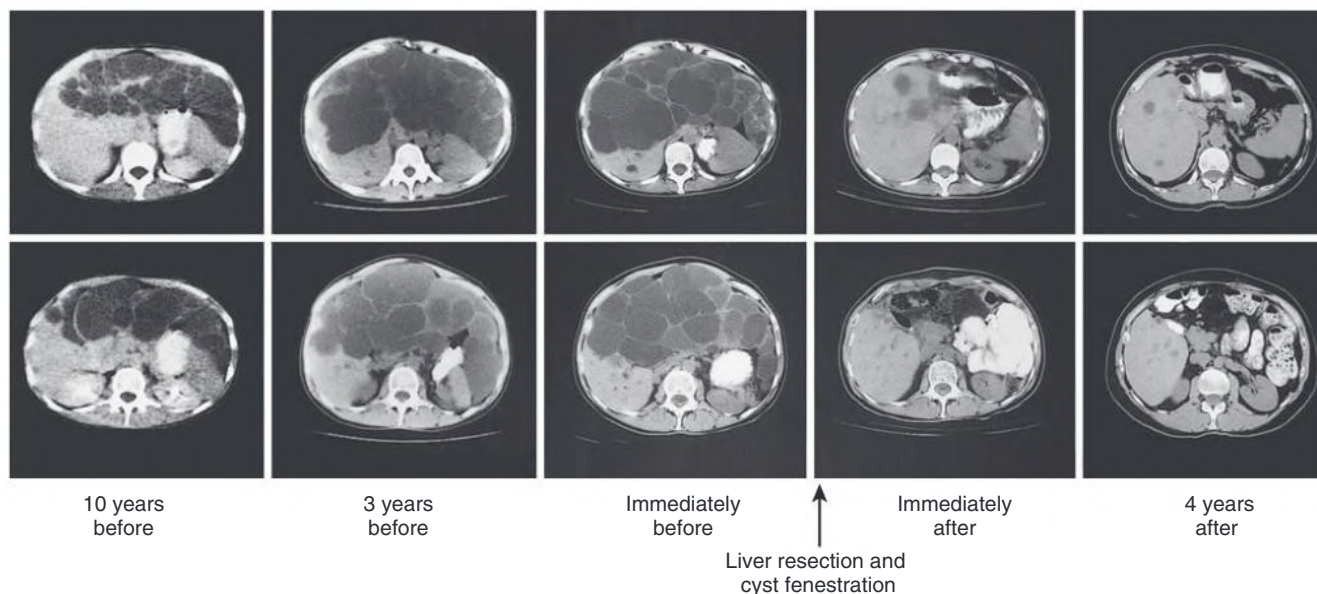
Hepatic Resection in Autosomal Dominant Polycystic Kidney Disease (ADPKD). Computed tomography scans of the abdomen from two patients with ADPKD obtained are 10 years before (column 1), 3 years before (column 2), immediately before (column 3), immediately after (column 4), and 4 years after (column 5) liver resection and cyst fenestration, demonstrating long-term, sustained reduction in liver size after the procedure.
